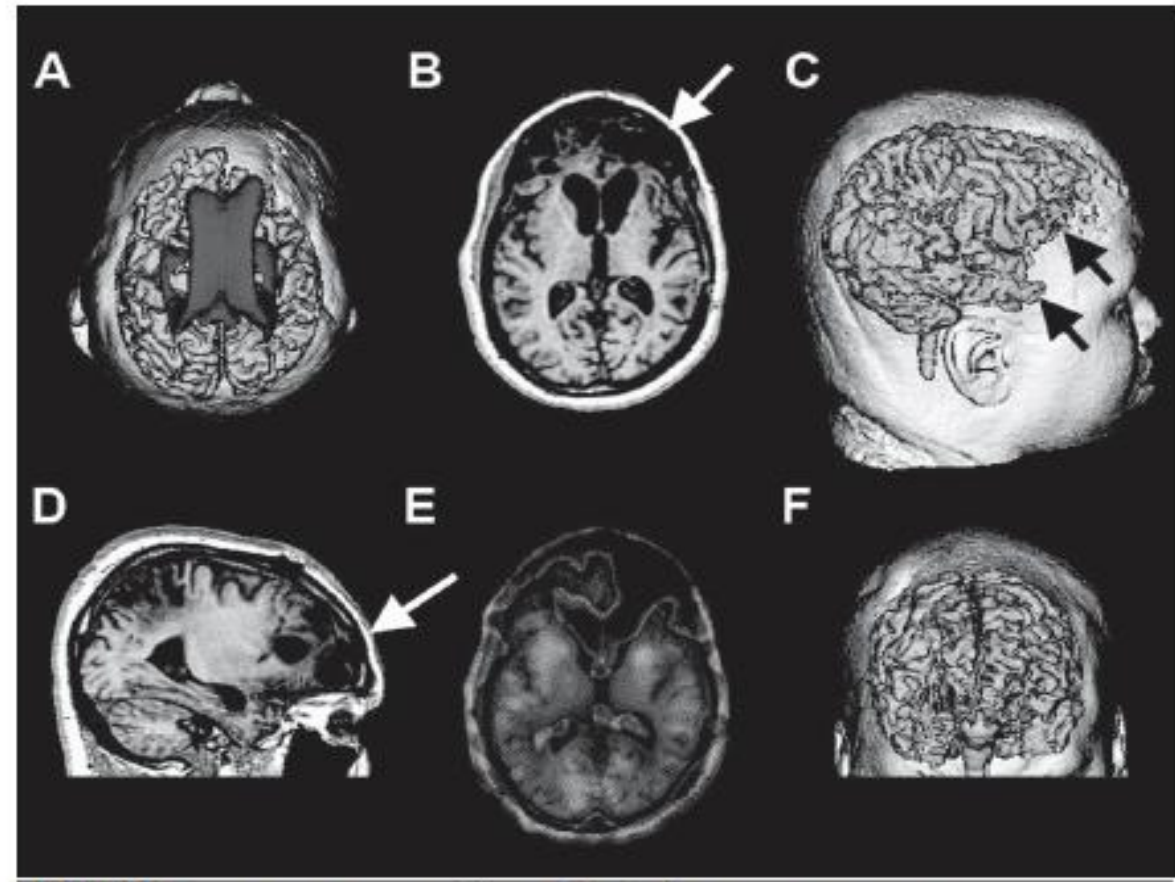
Neuroimaging in a case of dementia due to head trauma. (See color plate 10) Neuroimaging studies for the subject discussed in Figure 13–1. *B* is an axial T₁-weighted magnetic resonance imaging (MRI) image showing extensive frontal damage (white arrow) as a result of the severe traumatic brain injury (TBI). *D* is a sagittal T₁-weighted image showing the extensive frontal (white arrow) pathology present in this patient. *A*, *B*, and *F* all represent three-dimensional (3-D) reconstructions of the MRI as to visualize the ventricle (shown in blue) in the dorsal view in *A*, and the extensive frontotemporal wasting (black arrows) in *C* and by viewing the bifrontal atrophy, particularly in the inferior frontal region in *F*. *E* is the view of single photon emission computed tomography (SPECT) findings at the same axial level as depicted in *B*. Note the extensive loss of frontal perfusion on the SPECT image. Lastly, note the generalized ventricular dilation (see *H* in Figure 13–4 for what a normal dorsal view should appear like). These imaging findings clearly demonstrate diffuse brain damage and generalized TBV loss, wherein the dementia due to head trauma diagnosis was straightforward to make given these neuroimaging findings, in conjunction with the history and neuropsychological assessment findings.
